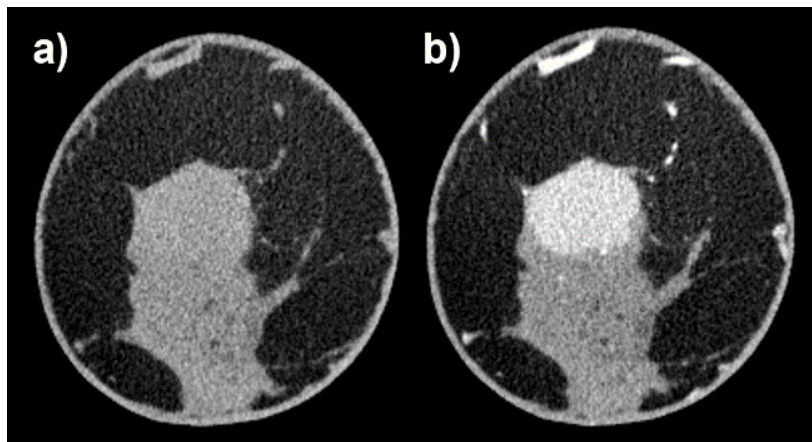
Pre-contrast (a) and post-contrast (b) coronal breast CT images of invasive mammary carcinoma. Local enhancement is visible in the post-contrast image.
